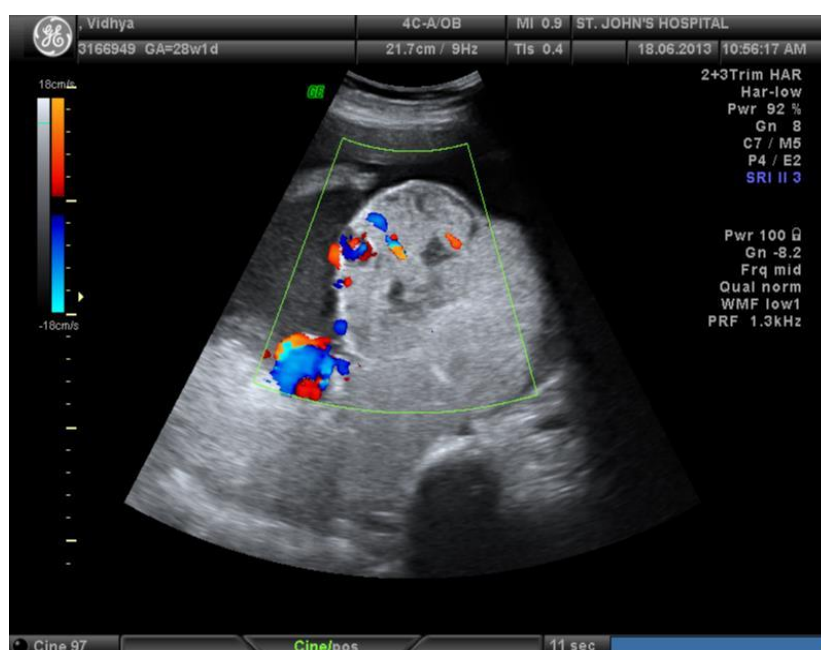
Doppler showing intratumoral vascularity
